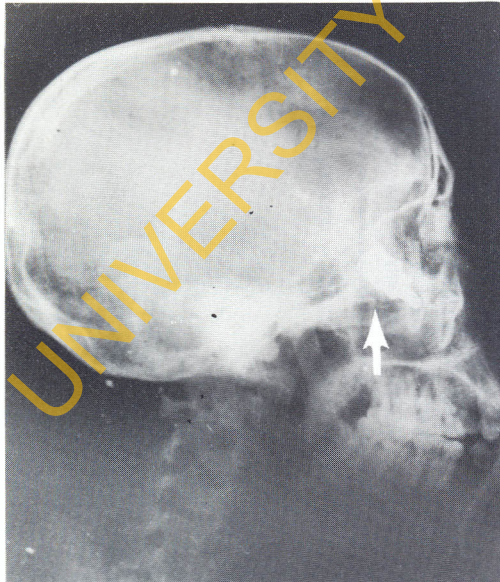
X-ray picture of a cap in the zygomatic region.
